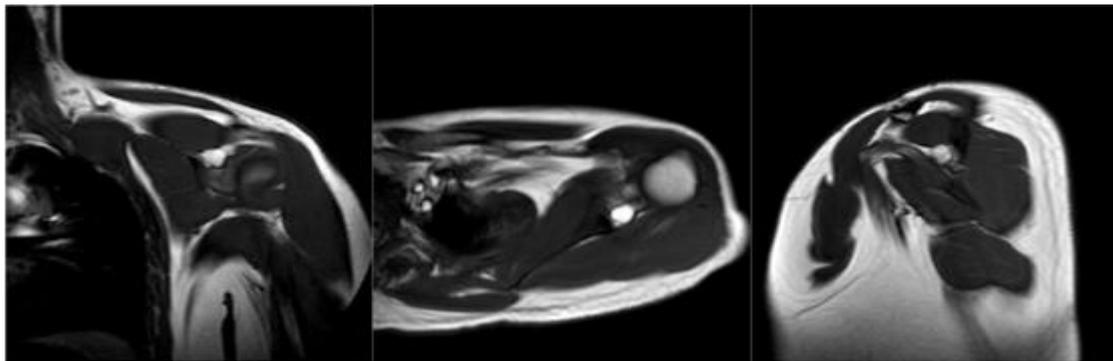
Magnetic resonance imaging picture showing paralabral cyst under the supraspinatus muscle.
